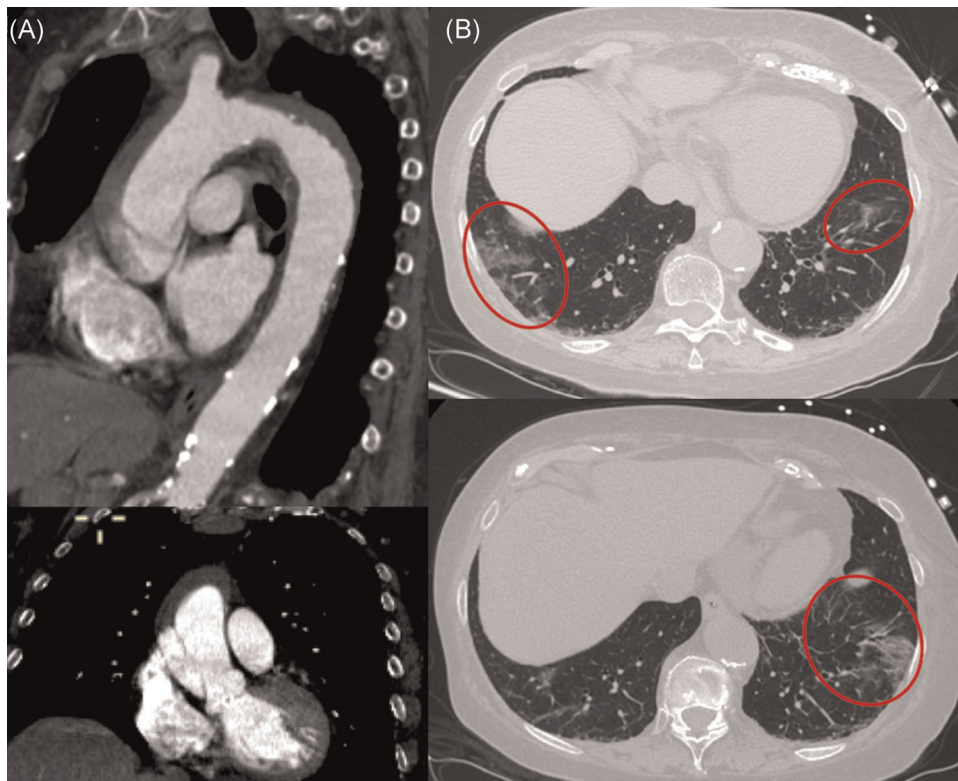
CTA of a patient with acute type A aortic dissection and suspicion of COVID-19 disease due to unspecific pulmonary infiltrates. COVID-19, coronavirus; CTA, computed tomography angiography
